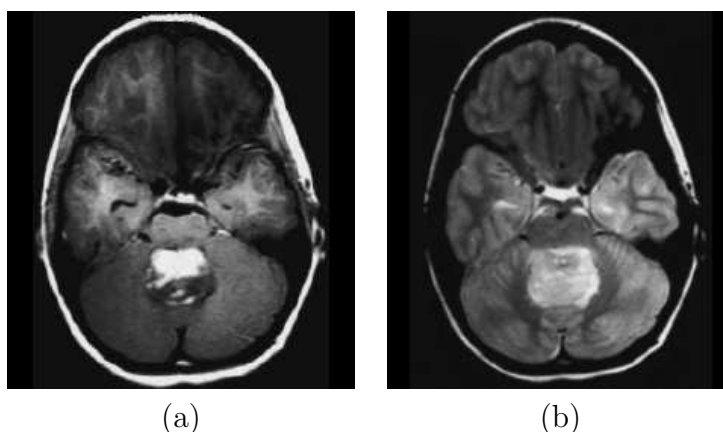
Medulloblastoma. a) Contrast enhanced axial T1-weighted image showing irregularly enhancing tumor in the cerebellar vermis. b) Axial T2-weighted MRI of the same patient showing increased signal in the tumor [Wen et al., 2001].
